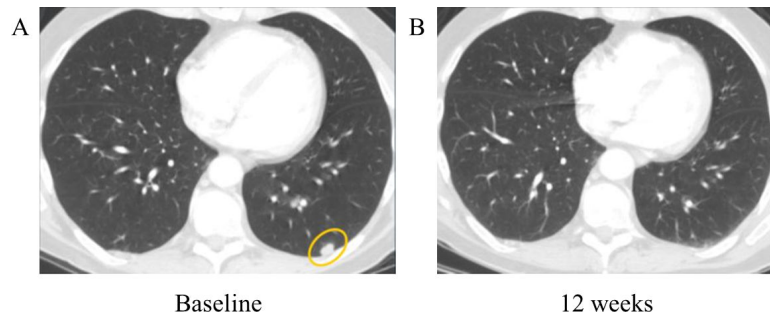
Tumor regression of 100% of measurable disease observed in lung tumors on CT scan at baseline (A) and after 12 weeks of treatment with trastuzumab, lapatinib, and bevacizumab (B).
